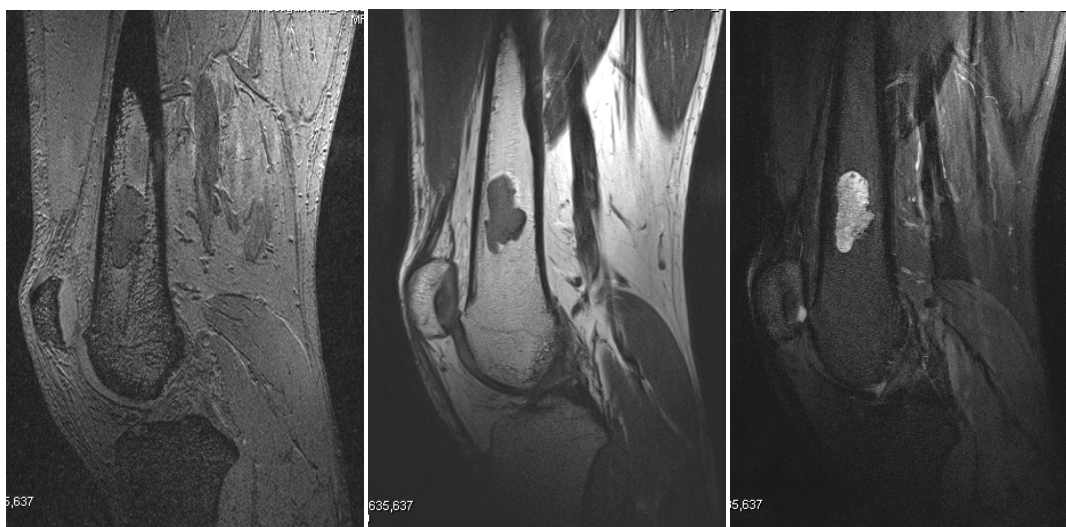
FLASH(left), TSE-T2 (center), and FLAIR (right) images of an enchondroma. The lesion is clearly visualized in all three contrasts. Note the large coverage of the coil, which allows assessing both the knee and the adjacent anatomy.
